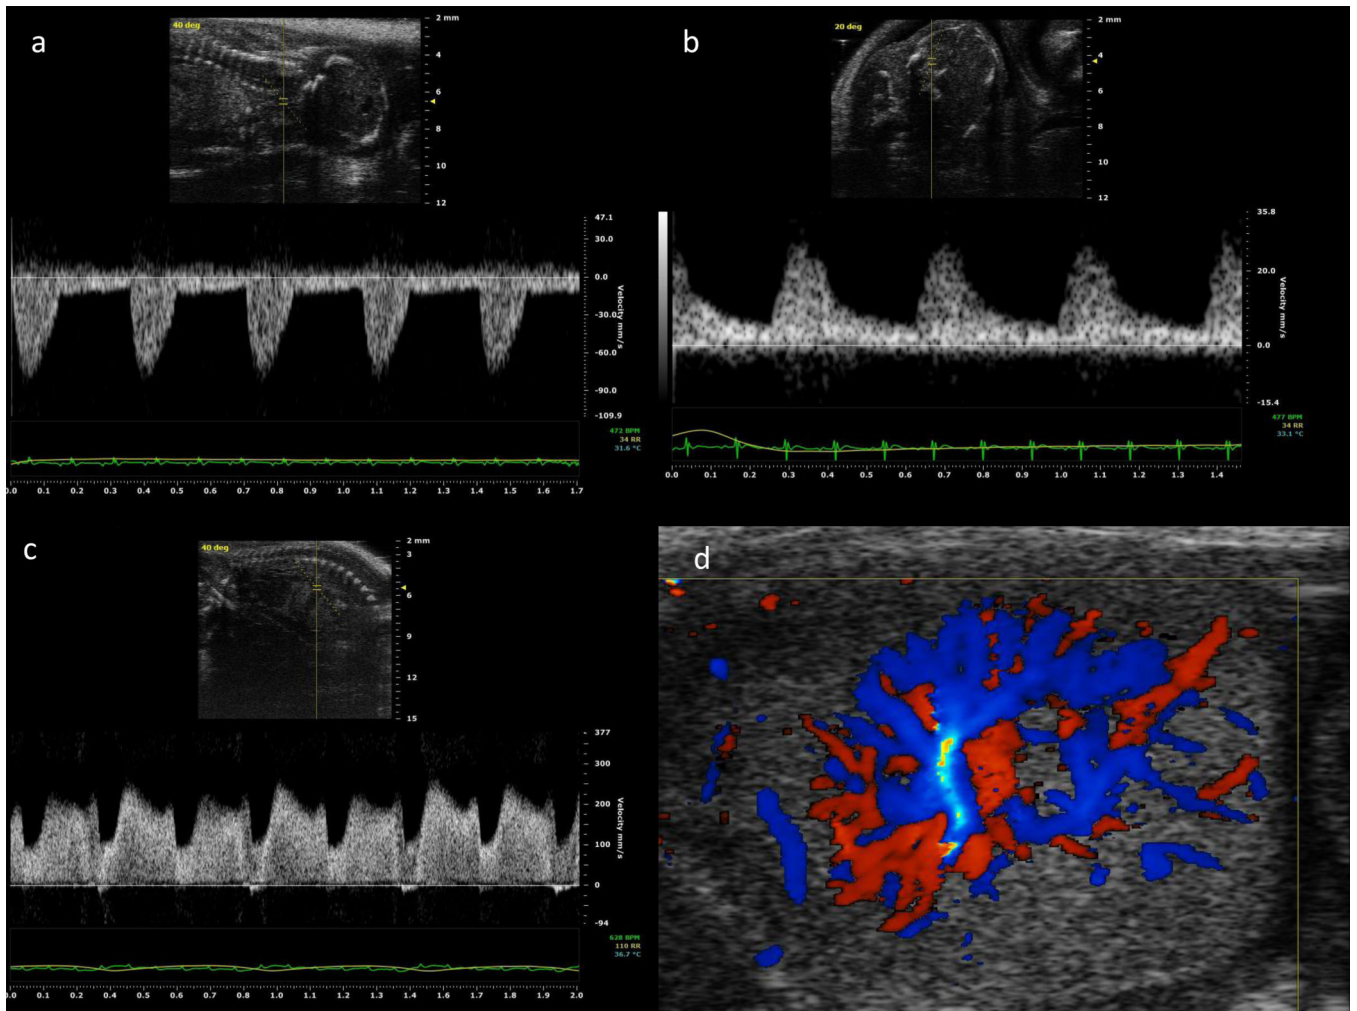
Doppler waveforms of: a) common carotid artery; b) middle cerebral artery; c) ductus venosus; and d) color Doppler velocimetry of intraplacental vessels at gestational day 16.
